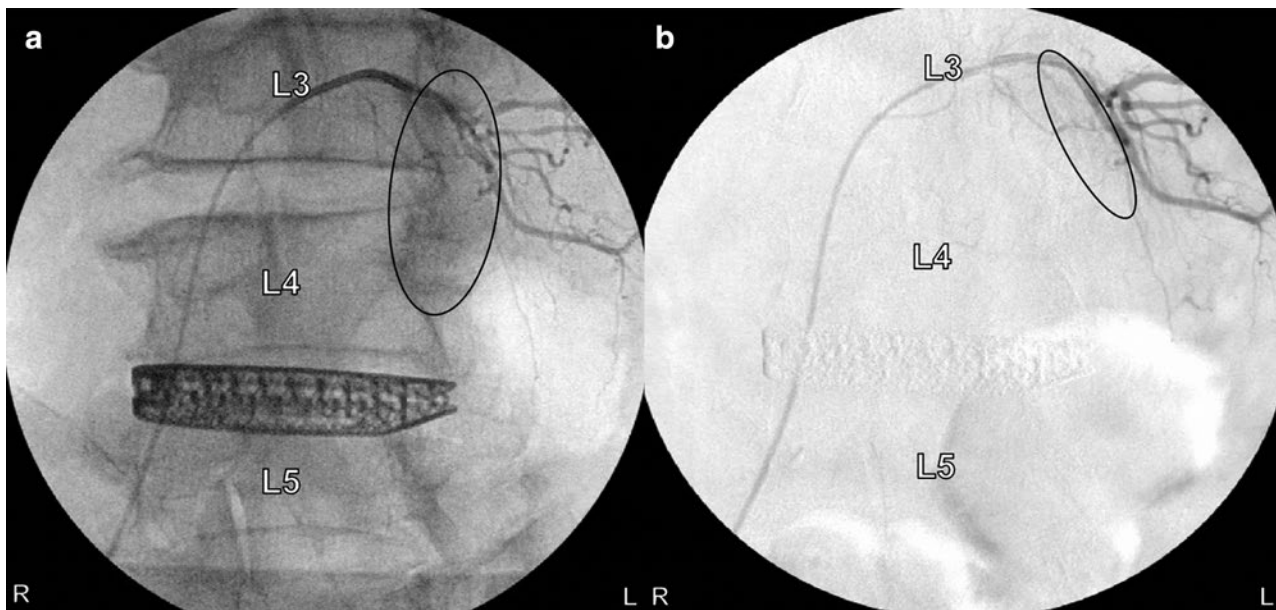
Intraoperative images before coil placement. (a) A still anteroposterior X-ray after dye injection into the left L3 segmental artery. The blush demonstrating active bleeding is encircled. Note how the segmental artery branches sag inferiorly and are tortuous. (b) A still image from a digitally subtracted anteroposterior angiogram is shown. A small area with a slight blush is encircled.
